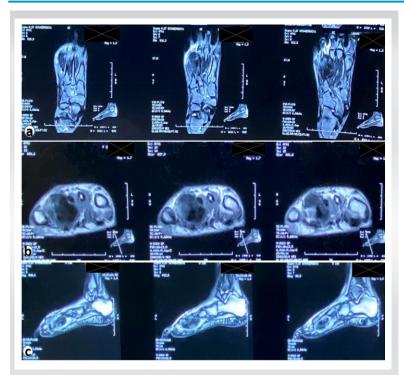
(a-c) Coronal, axial, and sagittal sections of magnetic resonance imaging of the left foot showing expansile hypointense lesion in T1 and T2 weighted imaging.
